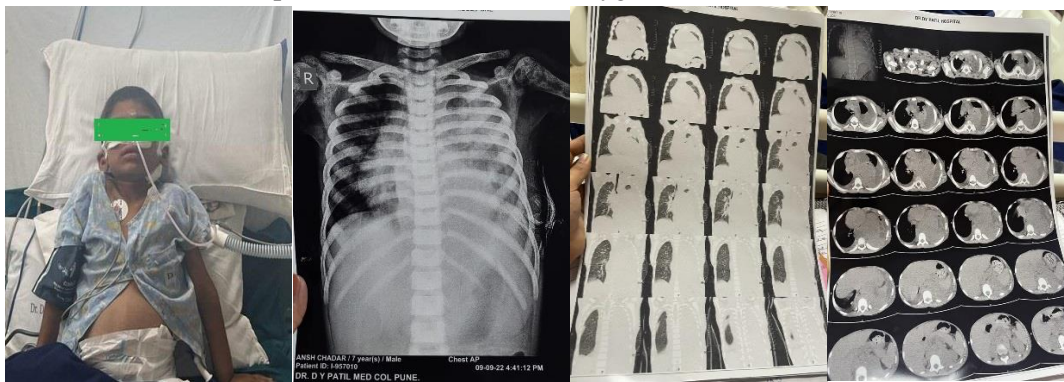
preoperative patient on HFM, Fig 2. Chest X-ray, Fig 3&4 HRCT Thorax
